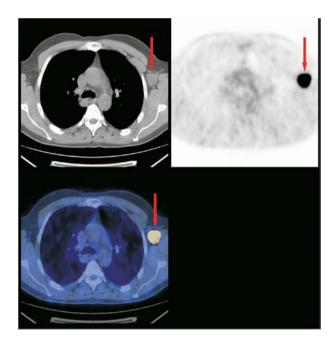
An axial image. Top left: CT image showing a 3 cm nodal mass in the left axilla (red arrow); top right: PET scan showing intense uptake; bottom left: fused PET/CT image shows active nodal recurrence in a patient with previous follicular non-Hodgkin's lymphoma.
